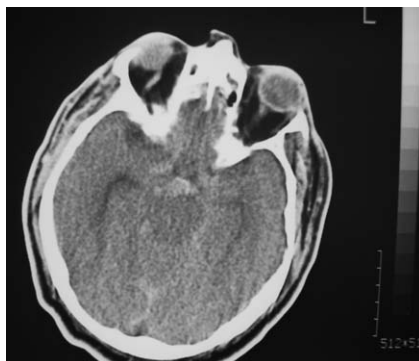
Cranial computed tomography revealed subarachnoid hemorrhage in the posterior fossa.
